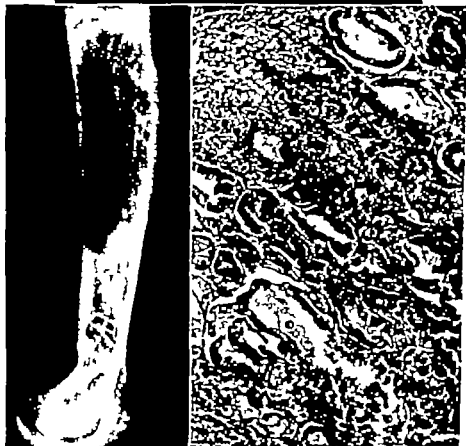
A B and C* Another instance in which biopsy of a metastatic focus in a humerus (*B* and *C*) led to the discovery of a hypernephroma of a kidney. Nephrectomy was followed by ablation of the involved upper limb in an attempt to obtain a cure (roentgen skeletal survey revealed no other discernible metastatic lesions). It is interesting to note that this patient had a remission for as long as 8 years before he manifested another tumor focus in a femur.
